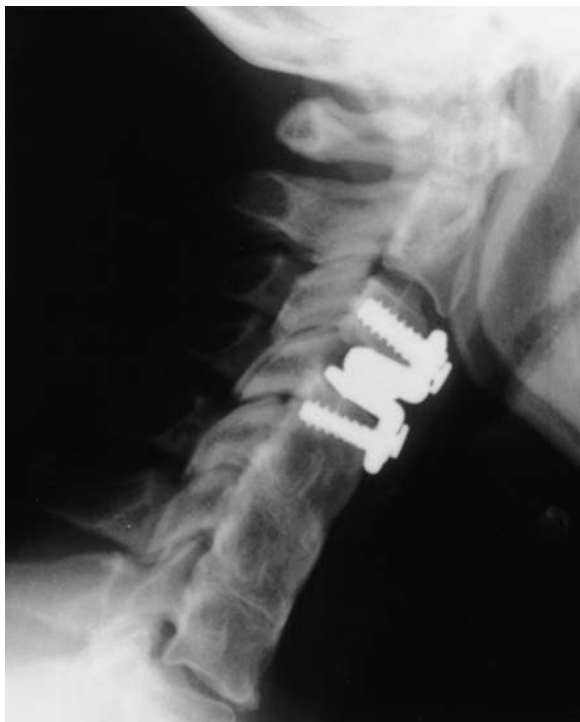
Representative radiograph of a cervical spine obtained in a patient in whom an ACJ was placed at C3–4 after having previously undergone multiple cervical interbody fusions.
